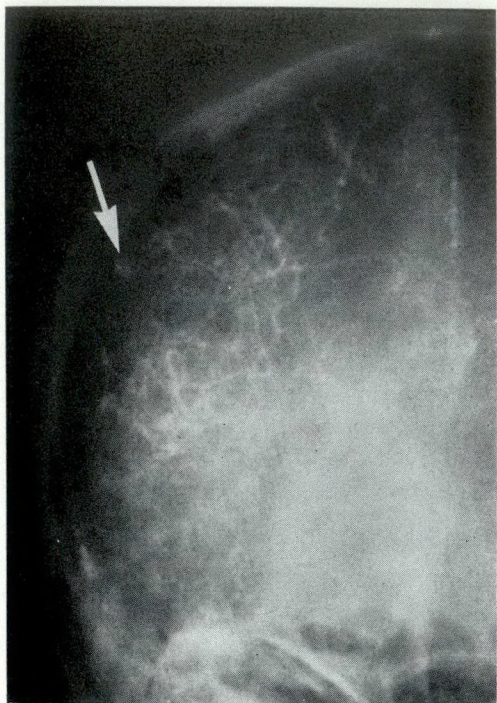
Radiographie de face, montrant une image anévrysmale à la région frontale postérieure et l'hématome sous-dural.
